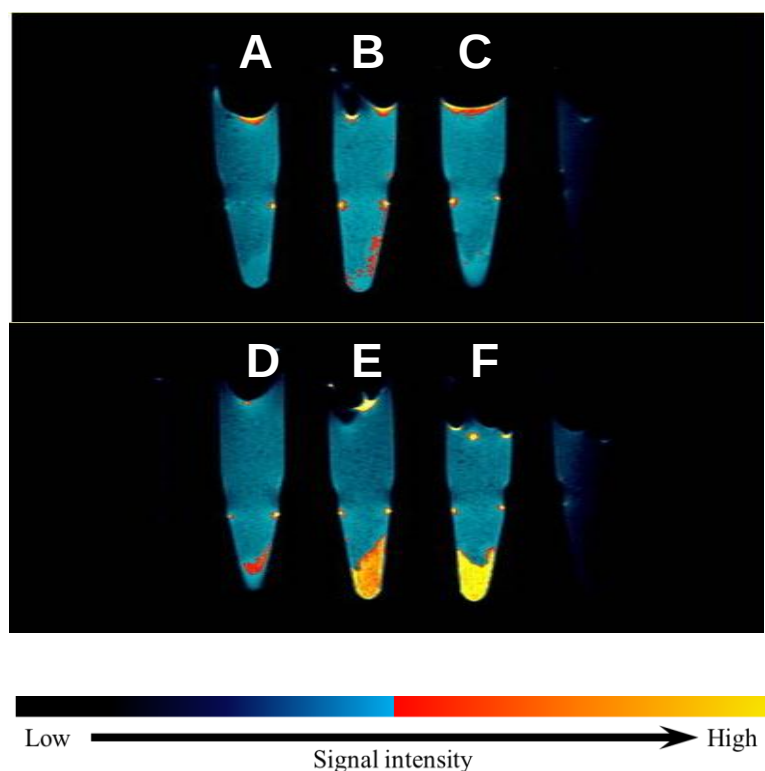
Representative T1-weighted MR images of Gd-DTPA-CDC pellets of different cell densities: (A) 0.01×10^6 , (B) 0.05×10^6 , (C) 0.125×10^6 , (D) 0.25×10^6 , (E) 0.5×10^6 and (F) 1×10^6 cells ($n=2$).
